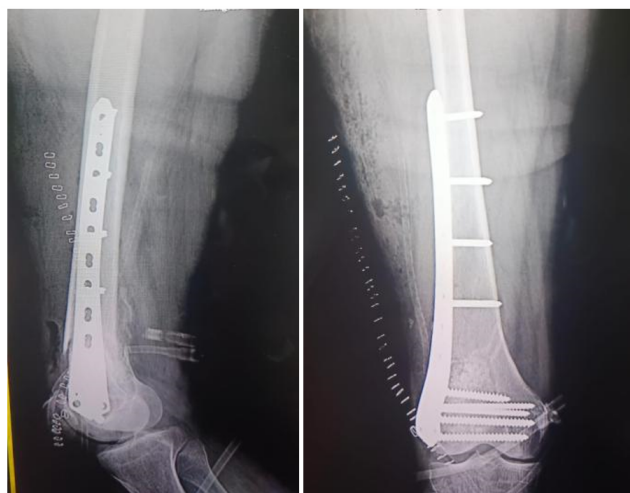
Immediate post op x-rays
